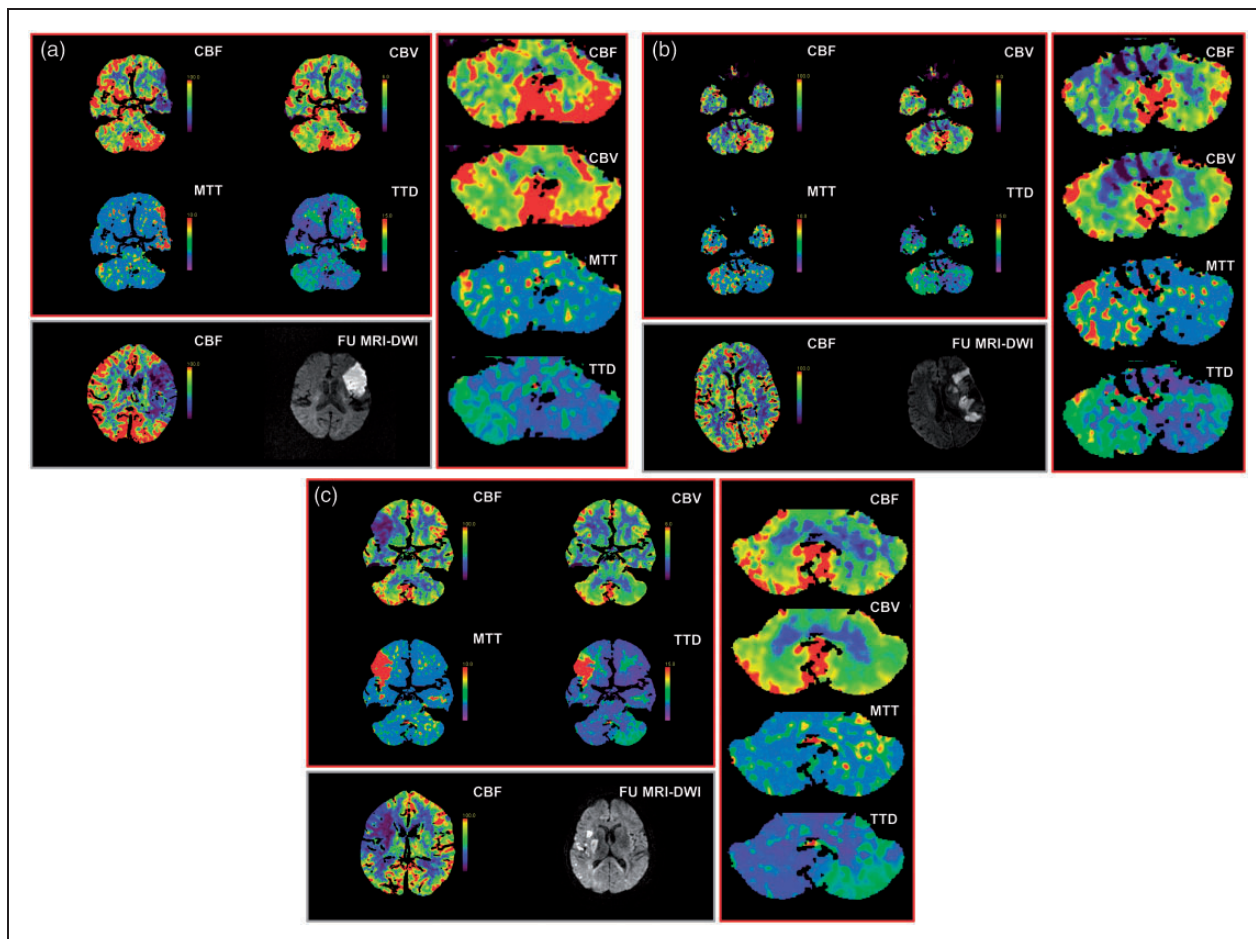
Representative cases of MCA infarction and CCD are shown in Figure 2 (a–c). CTP maps (CBF, CBV, MTT and TTD, right panel: higher resolution) of the cerebellar perfusion on admission are shown in the red frame. The infarcted tissue (CBF upon admission, corresponding follow-up MRI-DWI) is demonstrated within the grey frame. (a) Ninety year-old woman with acute right-sided hemiparesis, left-sided gaze preference and expressive aphasia. Time from symptom onset to CTP imaging was 75 min and to MRI follow-up 67 h, respectively. (b) Sixty-nine year-old woman with acute right-sided hemiparesis and global aphasia. Time from symptom onset to CTP imaging was 150 min and to follow-up MRI 71 h, respectively. (c) Sixty-five year-old woman with acute left-sided hemiplegia, dysarthria and a neglect. Time from symptom onset to CTP imaging was 120 min and to follow-up MRI 100 h. In all patients, rtPA was administered immediately after CT workup.
